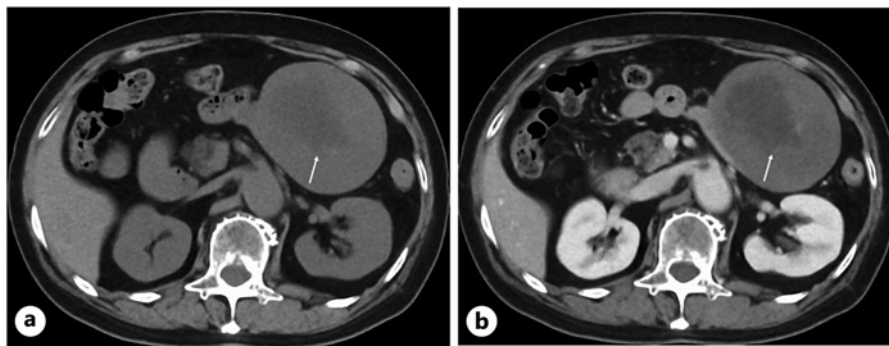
Computed tomography (CT) findings. a Plain CT showed an oval mass with a somewhat hypo-dense area (arrow) in the center of the tumor. b Contrast CT showed no contrast effect in the central area (arrow) and made the hypodensity more prominent.
